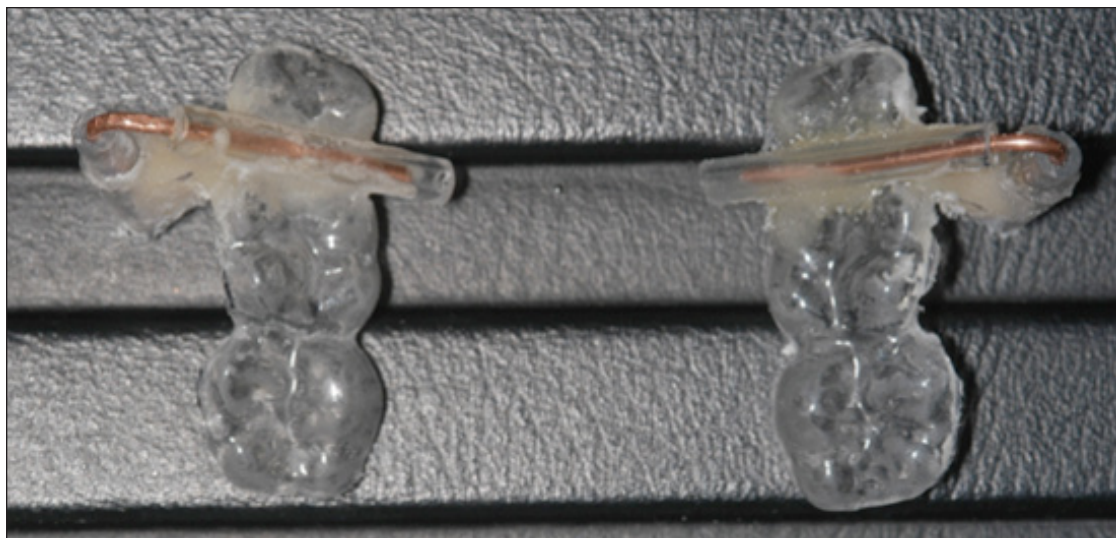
Pre-surgical intraoral radiograph, taken to confirm stent positioning. The positioning of the surgical stents seen in the radiographs are not ideal. Image below shows how the copper wire was repositioned prior to miniscrew placement.
